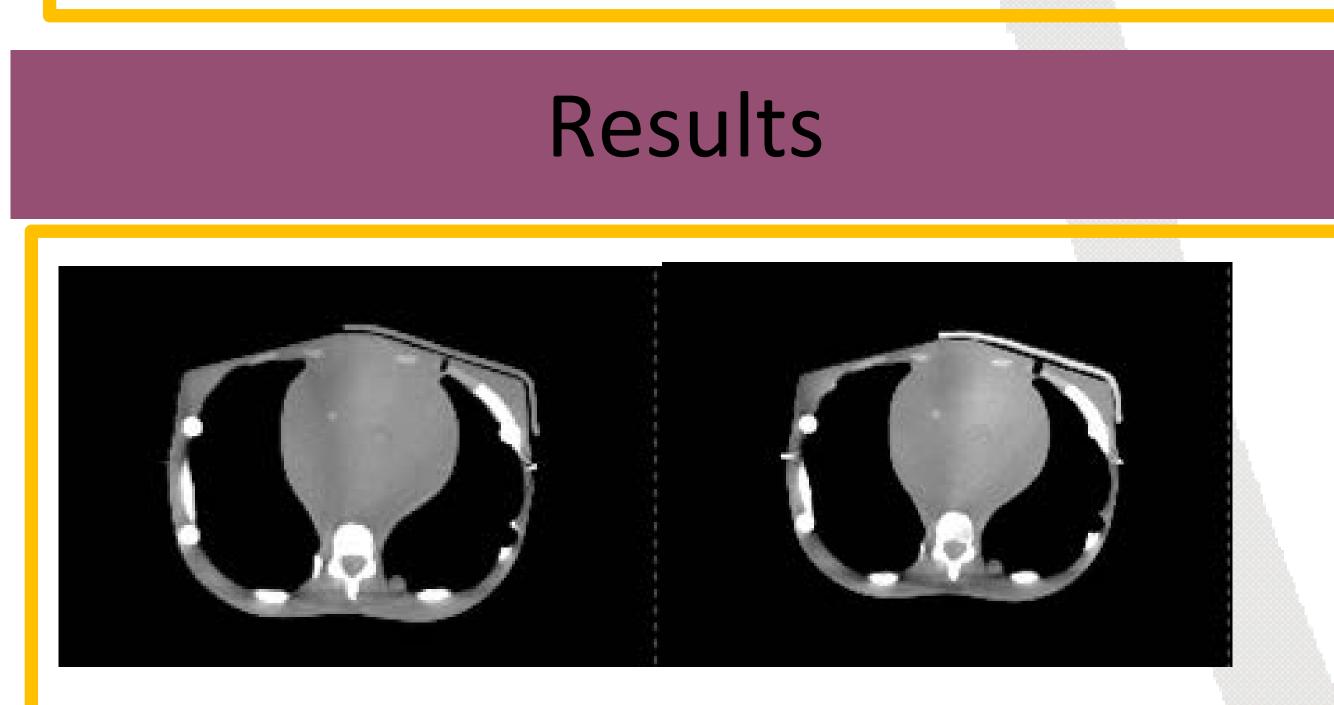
CBCT images of 3D-TPU (a) and 3DM-SIL (b) bolus.
